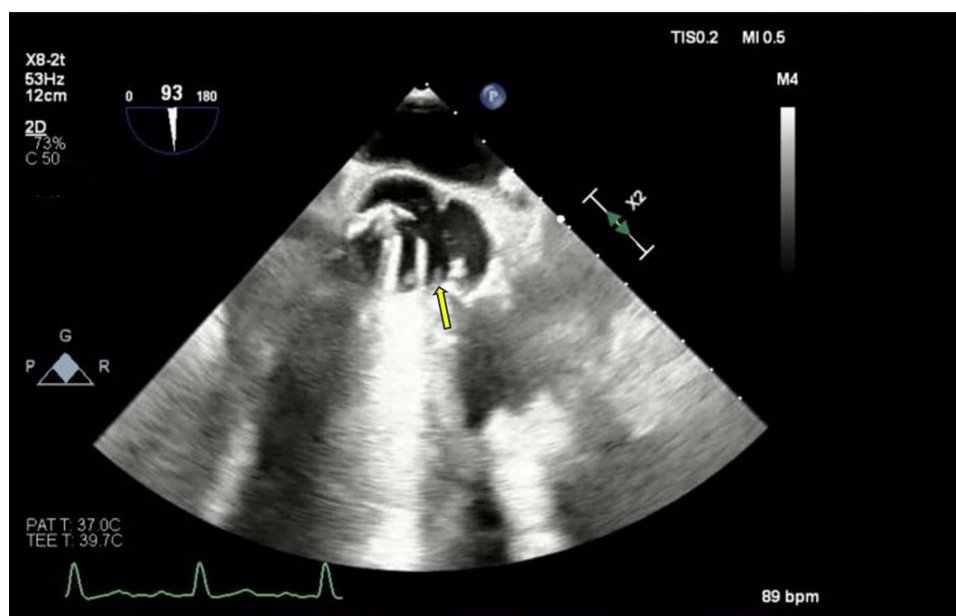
Transesophageal echocardiogram showed a 0.5*0.3cm vegetation attached to the aortic valve (yellow arrow) complicated by mild aortic regurgitation.
